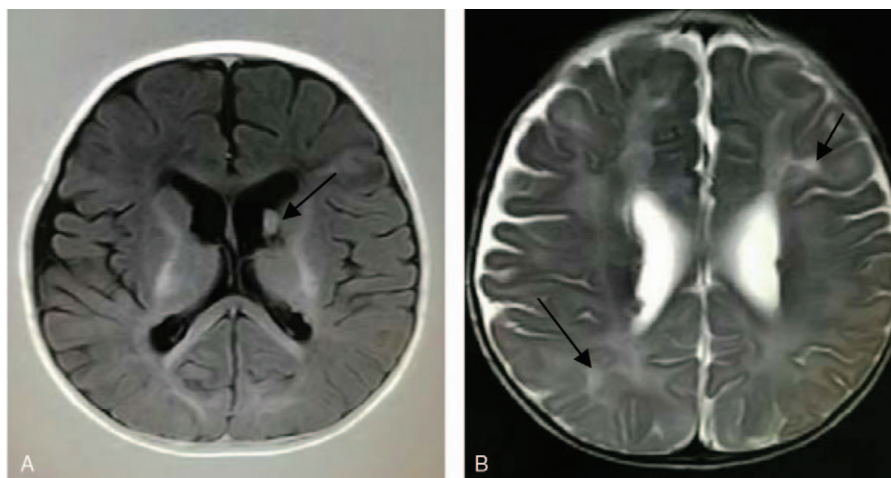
Brain MRI features of the proband in Family 2: (A) A subependymal giant cell astrocytoma of the right ventricle; (B) an abnormal patchy signal near the inferior horn of the lateral ventricle, frontal lobe, and parietal lobe.
